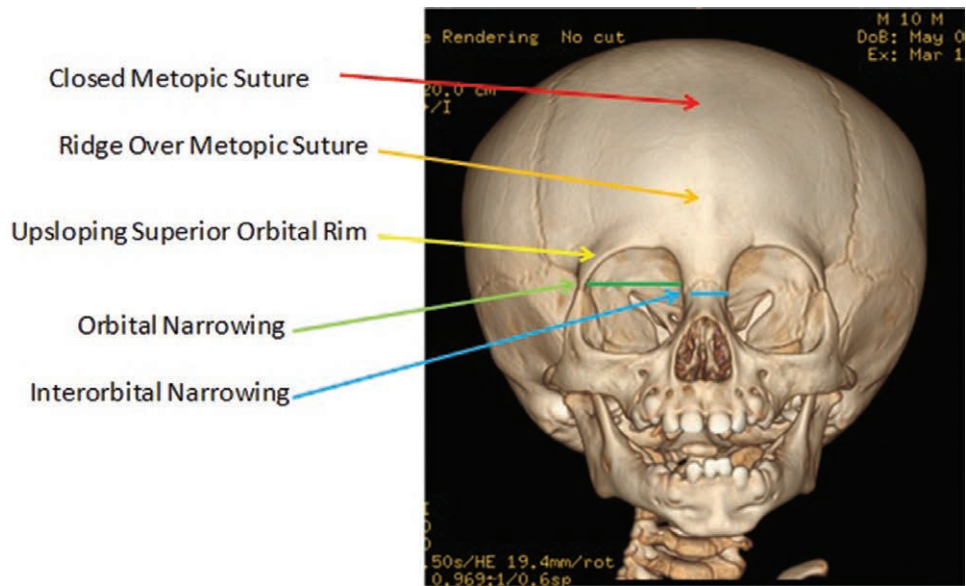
CT scan findings of orbital features and metopic suture features in MCS as evaluated by our expert raters.
